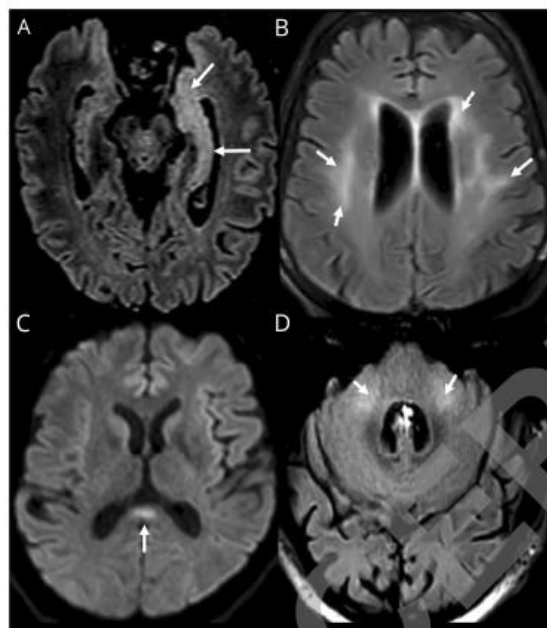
Encephalitis. Axial FLAIR (a,b,d) and diffusion (c) weighted MR images. Man aged 56 years: left hippocampus and amygdala FLAIR hyperintensity (a). Woman aged 71 years: periventricular and subcortical white matter FLAIR confluent hyperintensities (b). Man aged 55 years: corpus callosum splenium diffusion hyperintensity (c). Man aged 64 years: FLAIR middle cerebellar peduncles hyperintensity(d).
